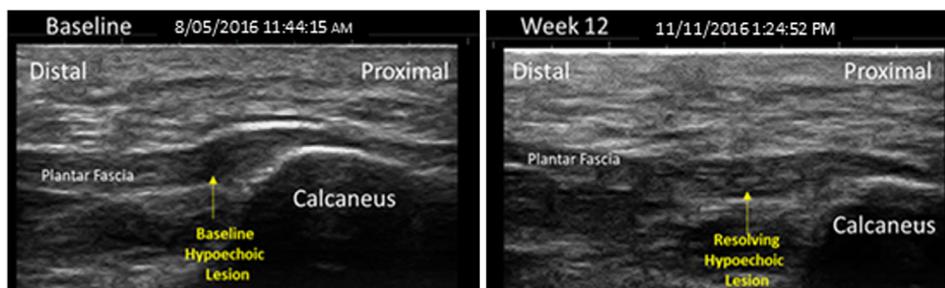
Long-axis ultrasound images of the proximal plantar fascia. Baseline image with hypoechoic lesion (left) and week 12 showing resolving hypoechoic lesion (right).
